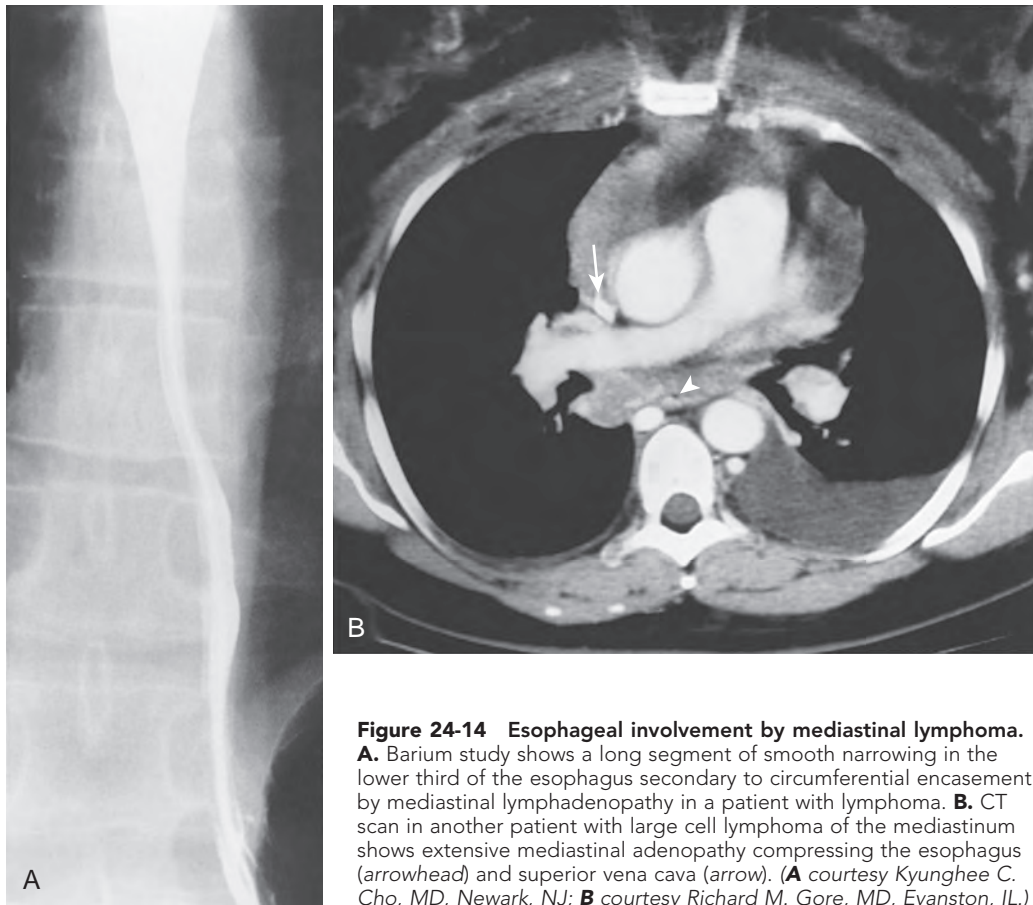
Esophageal involvement by mediastinal lymphoma. A. Barium study shows a long segment of smooth narrowing in the lower third of the esophagus secondary to circumferential encasement by mediastinal lymphadenopathy in a patient with lymphoma. B. CT scan in another patient with large cell lymphoma of the mediastinum shows extensive mediastinal adenopathy compressing the esophagus (arrowhead) and superior vena cava (arrow). (A courtesy Kyunghie C. Cho, MD, Newark, NJ; B courtesy Richard M. Gore, MD, Evanston, IL.)
